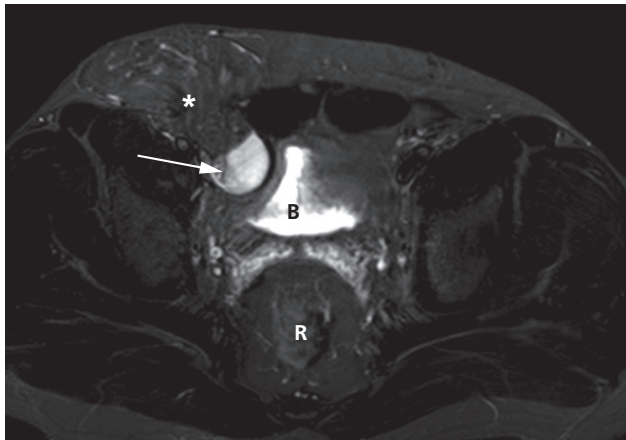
MRI of an undescended right testis (arrow). The testis lies in the region of the right inguinal canal and appears of very high signal on the T2-weighted image with fat saturation. There is also a right inguinal hernia containing fat (*). B, bladder; R, rectum.
